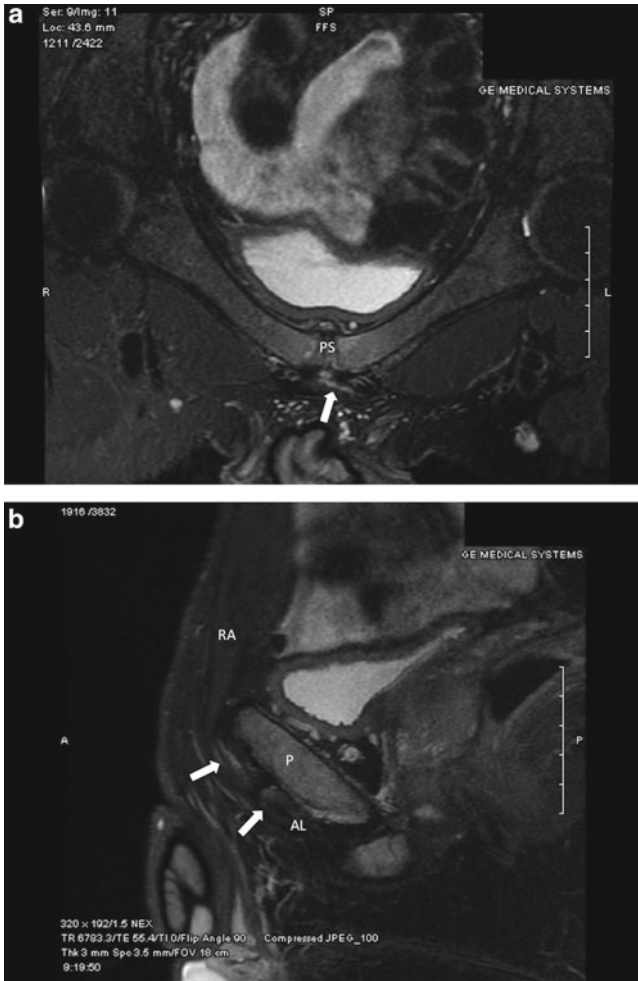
(a) T2-weighted axial oblique image of the pelvis demonstrating a cleft sign (*arrow*) just inferior to the pubic symphysis (PS); (b) T2-weighted sagittal image of the pelvis demonstrating hyperintense aponeurotic tears (*arrows*) of the rectus abdominis (RA) and adductor longus (AL) tendon insertions into the pubic bone (P).
